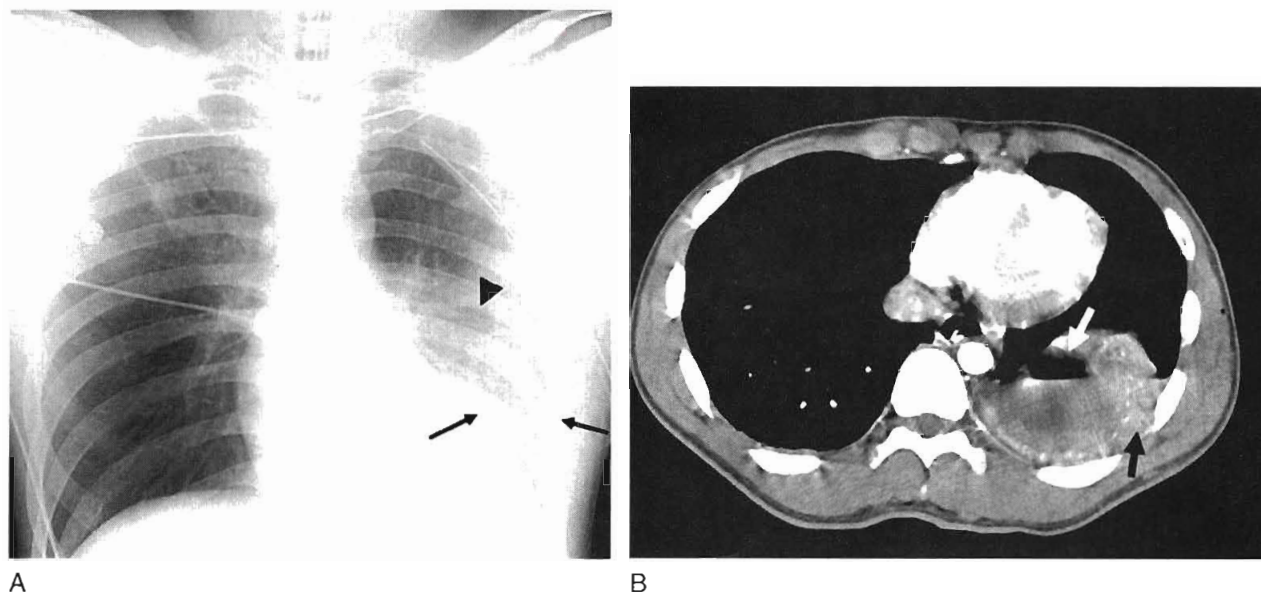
A 30-year-old man was involved in motor vehicle crash. A, Chest radiograph shows small lucent area (*arrowhead*) within area of the left lower lobe opacity (*arrows*). B, Axial CT image of the chest shows a "cavity" with an air-fluid level (*white arrow*) in the left lower lobe, representing a pulmonary laceration surrounded by pulmonary contusion and hemorrhage (*black arrow*).
